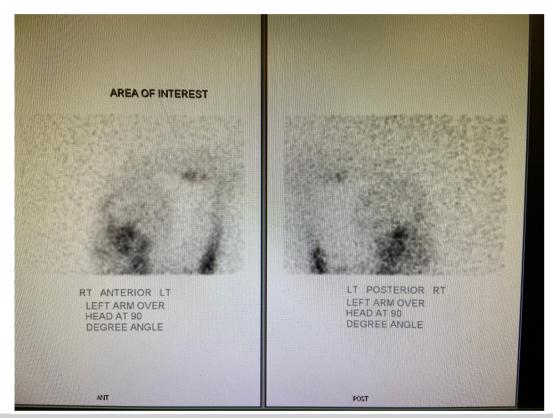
White blood cell scintigraphy (WBCS) scan with localization at the graft site. *ANT*, anterior; *LT*, left; *POST*, posterior; *RT*, right.
